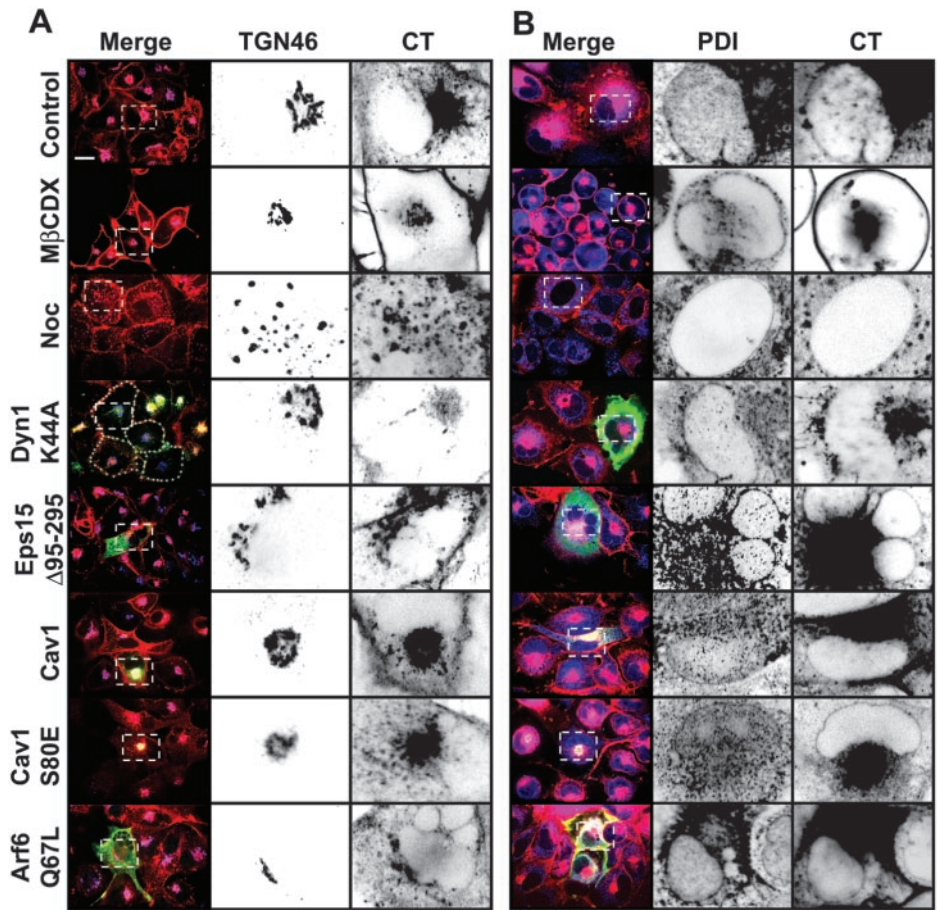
Combined inhibition of the clathrin-, caveolin-, and Arf6-dependent pathways strongly inhibits CT entry. (A) Inhibition of clathrin-, caveolin-, or Arf6-dependent pathways has minimal
